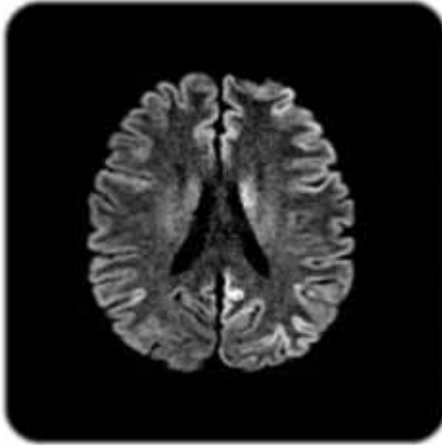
DWI sequence N.Caudatus
